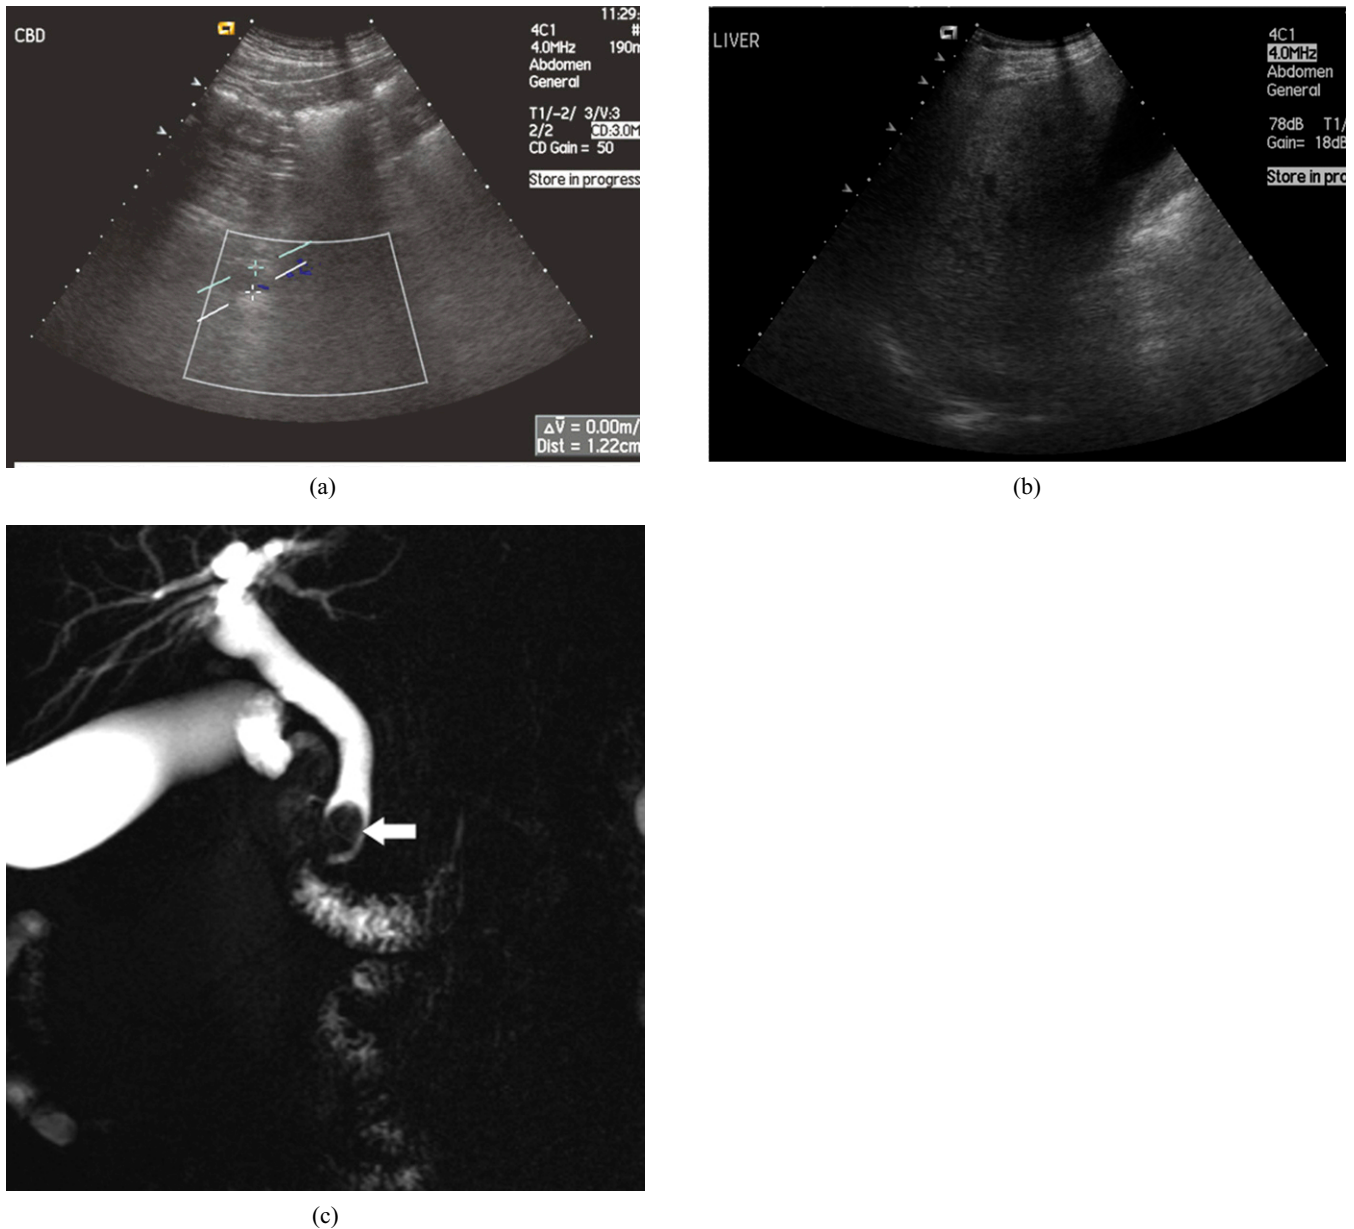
A 50-year-old overweight man presented with abdominal pain and abnormal liver function tests. Ultrasound of abdomen-limited assessment was carried out. Fatty infiltration of the liver (a) and a dilated common bile duct (CBD) were detected. Poor view of distal CBD (b). (c) Coronal maximum intensity projection image shows obstructing stone in the lower CBD (white arrow). Patient underwent endoscopic retrograde cholangiopancreatography and sphincterotomy.
